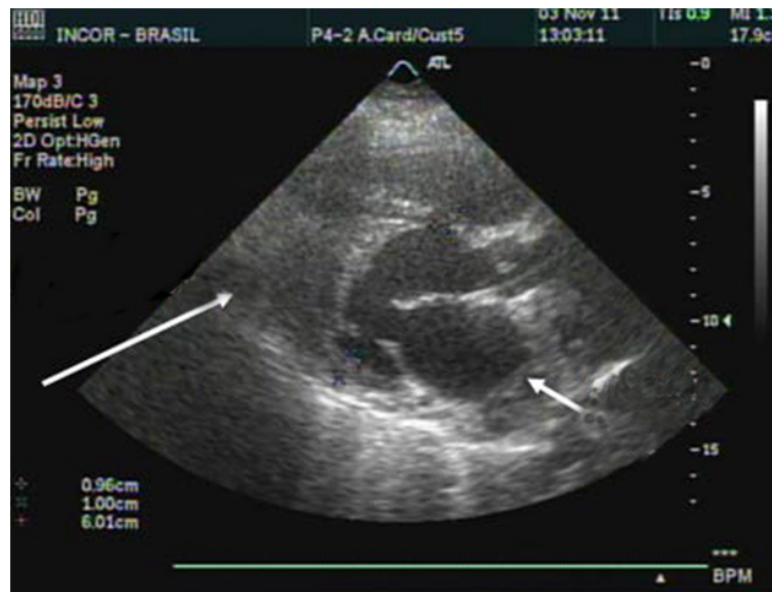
Parasternal, long-axis transthoracic echocardiogram: left atrium (short arrow) dilation and amputation of the left ventricular apex (long arrow).
